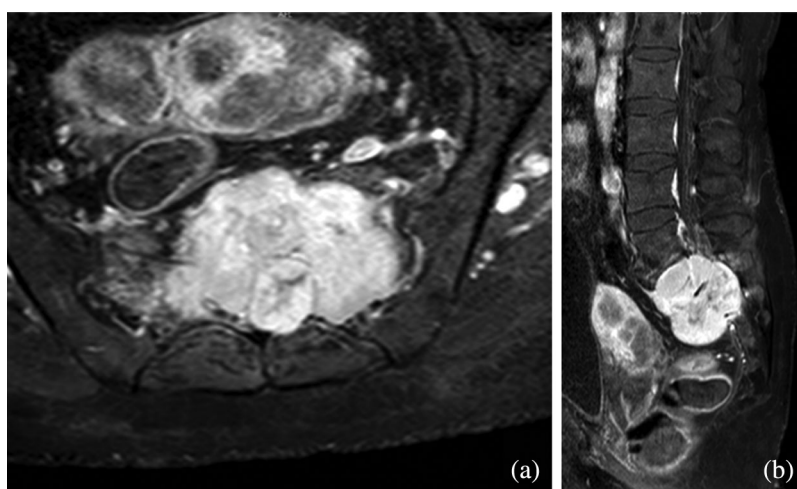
Contrast enhanced T1 weighted MRI. Homogenous uptake of contrast of the lesion encompassing the S1 and S2 vertebral bodies in total and obliterating the spinal canal with a predominance of the left side (a: axial, b: sagittal view)
